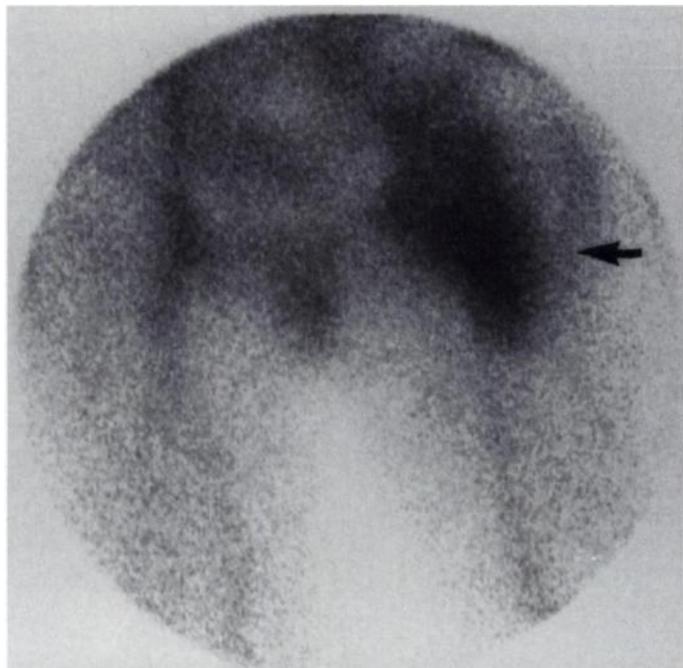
A 53-yr-old woman was referred from another hospital because of fever of more than 3 wk duration. She also had a painful hip. Blood cultures grew *S. aureus* and echocardiography revealed vegetations on the mitral valve. The ^{111}In -IgG scintigraphy revealed metastatic abscesses in hip femur, skull and chest. A culture of material obtained by puncture of the hip grew *S. aureus*. After antibiotic therapy, the patient underwent cardiosurgery for valve replacement. Thereafter, her fever disappeared (Patient 9).
